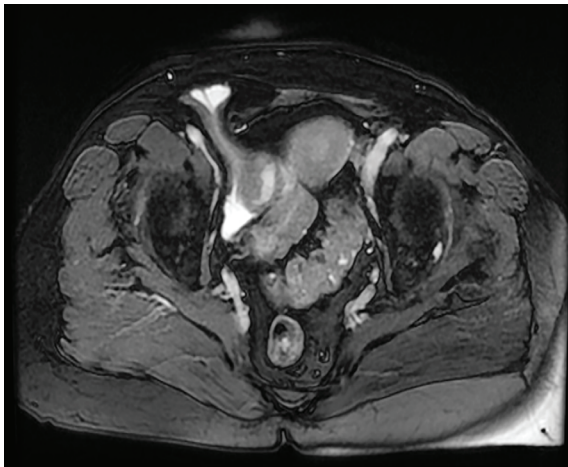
Magnetic resonance imaging showed the cystic lesion in the right inguinal area.
